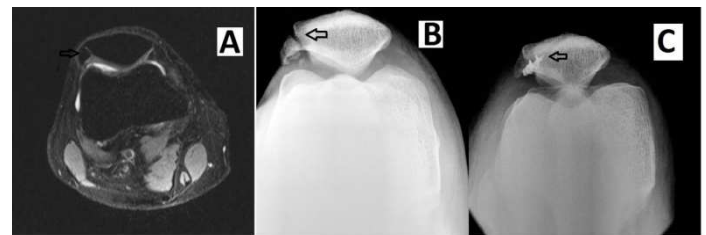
MRI image (A) and the axial radiograph of the knee (B) showing a symptomatic bipartite patella (arrow). The post operative axial radiograph of the knee (C), after the excision of the symptomatic bipartite patella and reattachment of the quadriceps.
